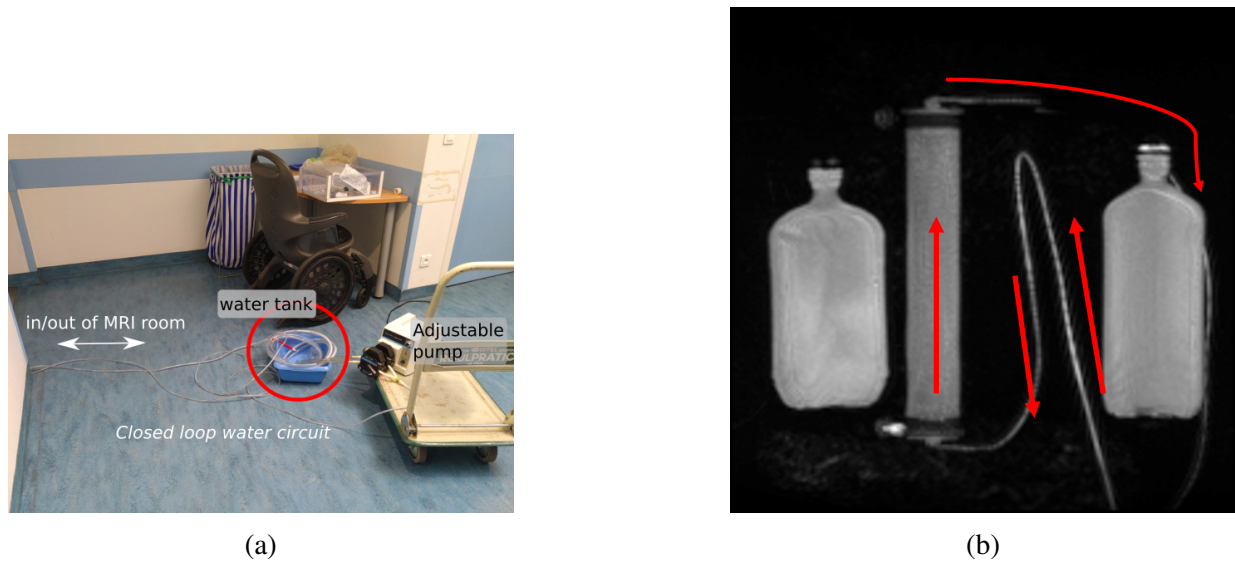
(a) Basin of water (encircled) with tubes coming in and out, connected to the water pump on the right. The MRI room is located to the left of the basin. (b) Top view of the set-up inside of the MRI. Left to right: bottle 1, dialyzer, tube 2 and 1, bottle 2, tube 3. The arrows indicate the direction of the flow through the tubes and dialyzer.
